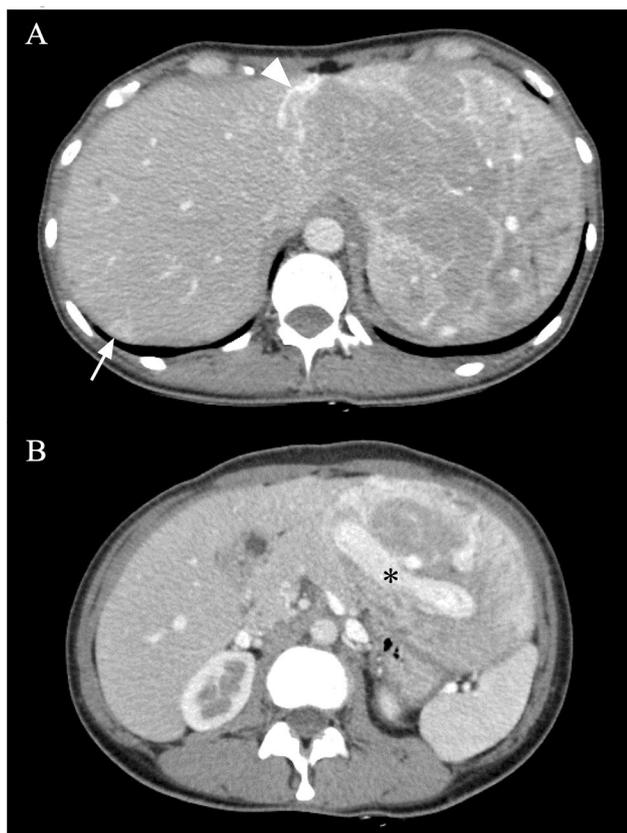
Contrast-enhanced computed tomography (CT) findings. a Abdominal CT showed a large hepatic tumor in the left lobe and another small hepatic tumor in the right lobe (arrow). An early drainage vein into the hepatic vein from the tumor may be seen (arrowhead). b A dilated and tortuous vessel (asterisk) can be seen inside the tumor in the left hepatic lobe
